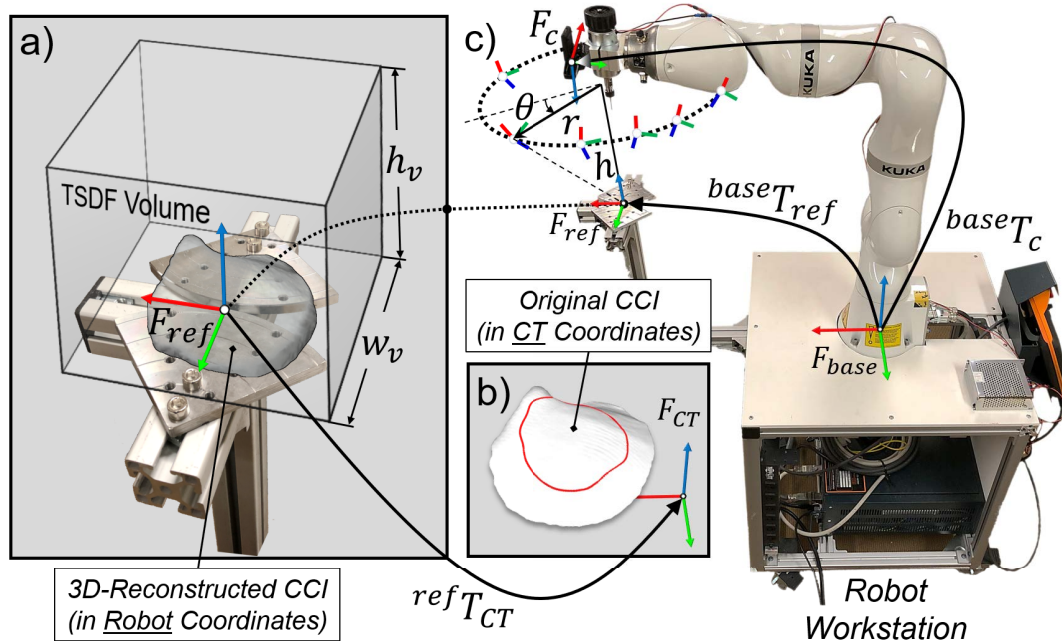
Automatic implant localization a) A 3D model of the implant is reconstructed in the robot space via TSDF fusion. b) The implant from the CT space is registered to the robot space. c) A circular path of radius r and height h above the implant is planned to perform robotic 3D scanning.
